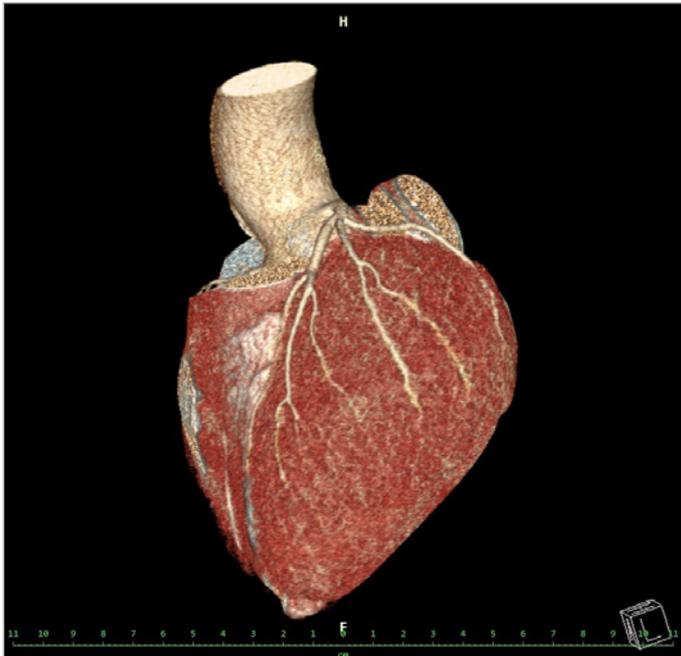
Negative CT coronary angiography.
